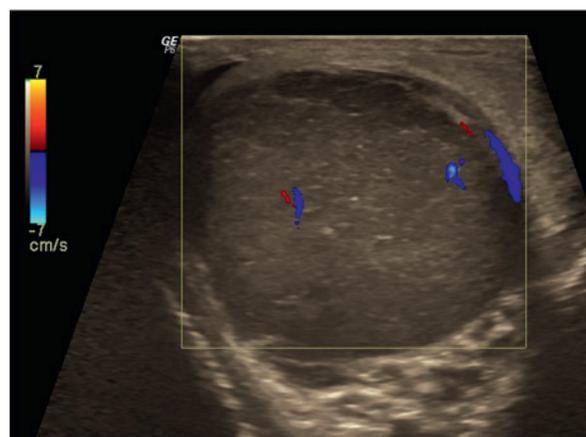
Ultrasound imaging of the scrotum. Testicular tumor
